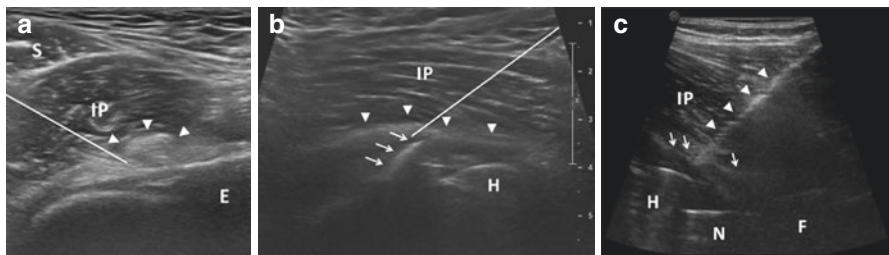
Injection under ultrasound guidance. Lateral to medial approach (a) *IP* iliopsoas; arrowheads, iliopsoas tendon; *S* sartorius, *E* iliopsoas eminence; white line, needle path. Sagittal approach (b) *H* prosthetic head; *IP* iliopsoas; arrowheads, iliopsoas tendon; arrows, prosthetic cup determining friction; white line, needle path. Sagittal approach (c) *IP* iliopsoas; arrow, iliopsoas tendon; arrowheads, needle; *H* prosthetic head; *N* prosthetic neck; *F* femur
